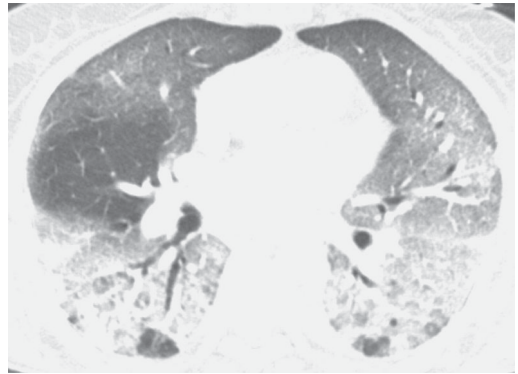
Chest CT scan demonstrating bibasilar consolidation with bilateral ground-glass opacities.
